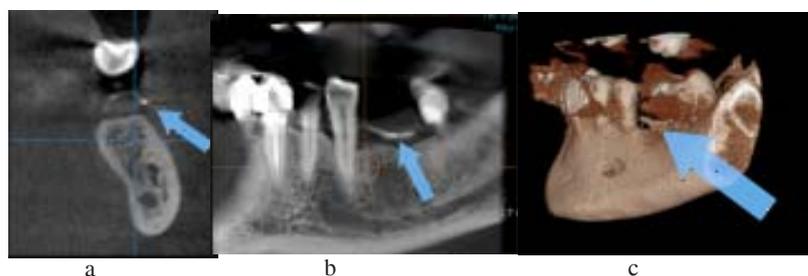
(a), (b) Radiographic aspects and (c) lateral view of the 3D reconstruction after inserting the ZrO_2 solution in the periodontal pockets
